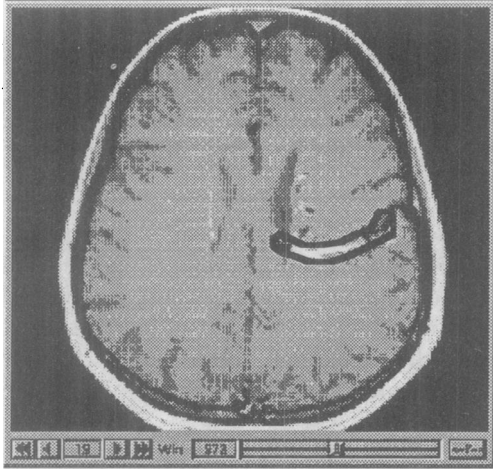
CT slice of tumor (middle right) used in testing.
